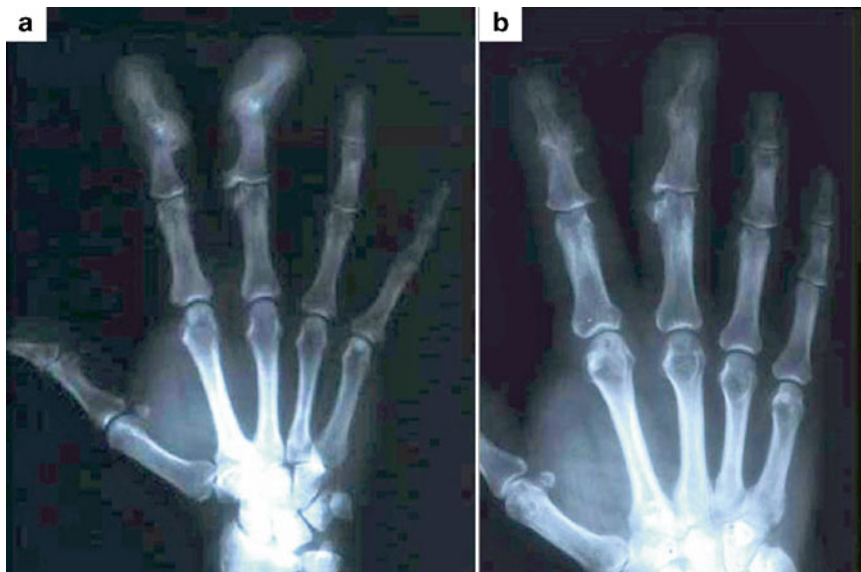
(a) Pre- and (b) postoperative radiographs showing correction of angulation of the distal interphalangeal joint (DIPJ) of the middle finger, and hyperostosis of the DIPJ of the index finger, in conjunction with soft tissue debulking in an adult patient
